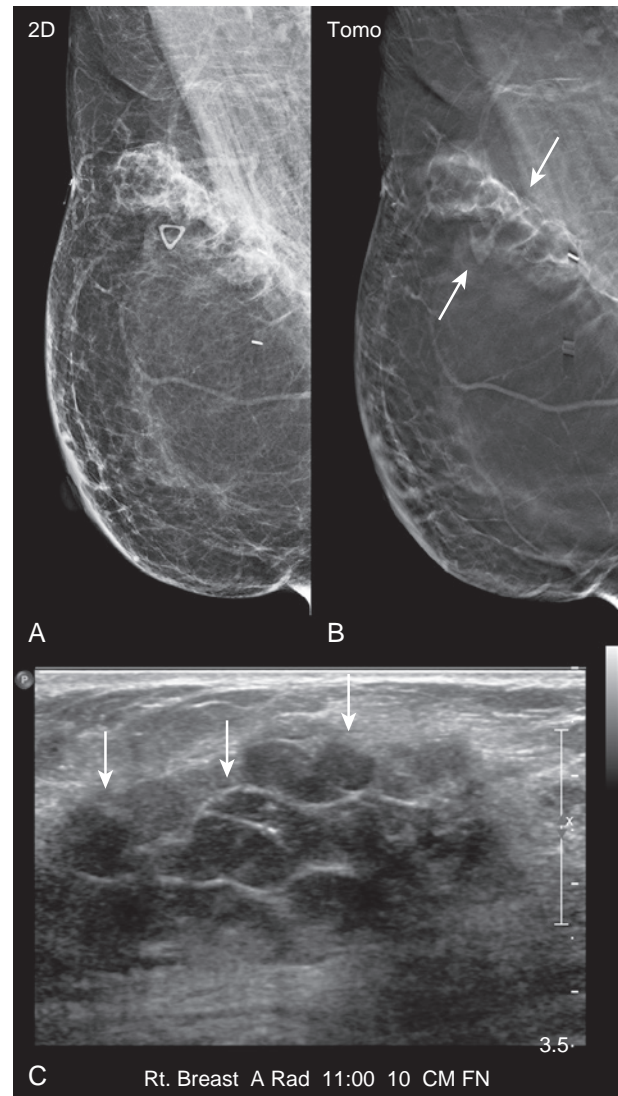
Breast reconstruction following mastectomy and palpable fat necrosis. A 62-year-old woman with a history of invasive carcinoma treated with mastectomy and deep inferior epigastric perforator flap reconstruction reports palpable masses in the upper outer quadrant of the reconstructed breast following surgery. (A) A two-dimensional image shows a regional, ill-defined asymmetry with associated oval lucencies corresponding to the palpable finding (triangle skin marker). (B) Better seen with tomosynthesis are multiple oval lucencies consistent with benign fat necrosis (arrows). (C) On targeted ultrasound the appearance is less specific.
